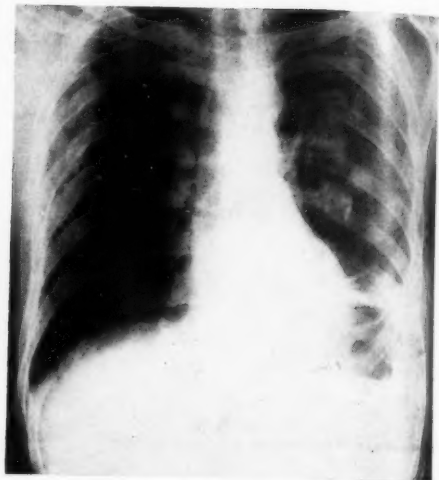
X-ray of case 1 at the time of leaving hospital.
